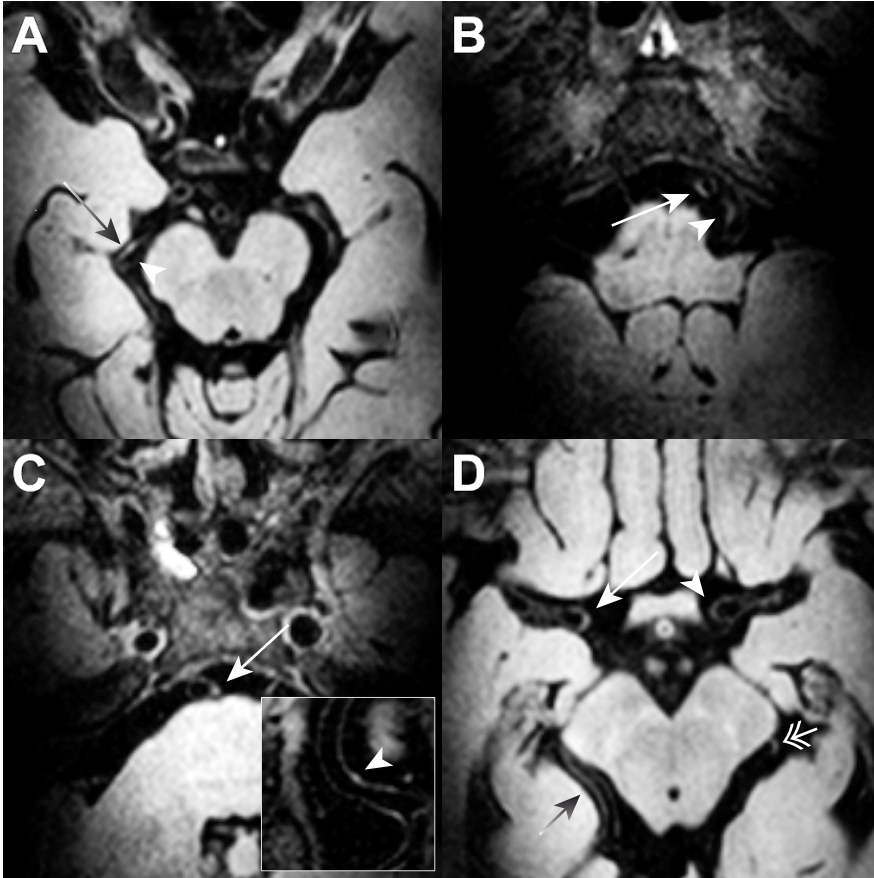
Examples of intracranial vessel wall lesions on vessel wall-MRI in a 76-year-old male patient with a history of coronary artery disease. A detailed description of rating criteria can be found in the methods section. A) Lesion in lateral wall of right P2 segment (arrow) versus non-discernable normal neighboring medial wall (arrowhead). B) Lesion in right vertebral (arrow) and left vertebral (arrowhead) artery. C) Lesion in proximal basilar artery (arrow), with coronal orientation shown in enclosed panel (arrowhead). D) Lesion in C7 segment of the right ICA (arrow), when compared to normal-appearing contralateral C7 segment (arrowhead) and proximal right M1 segment. Furthermore, note the long lesion in the distal half of the right P2 segment (grey arrow), and focal lesion in the left P2 segment (dual arrow).
